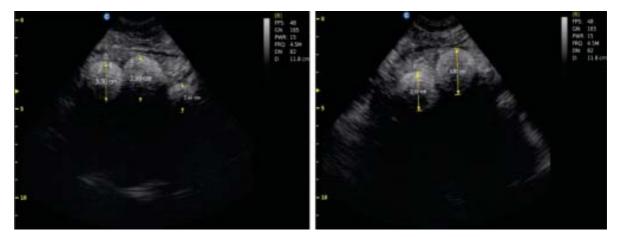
Ultrasound Evaluation of Vitelogenic Follicle of the Prefemoral Acoustic Window.
